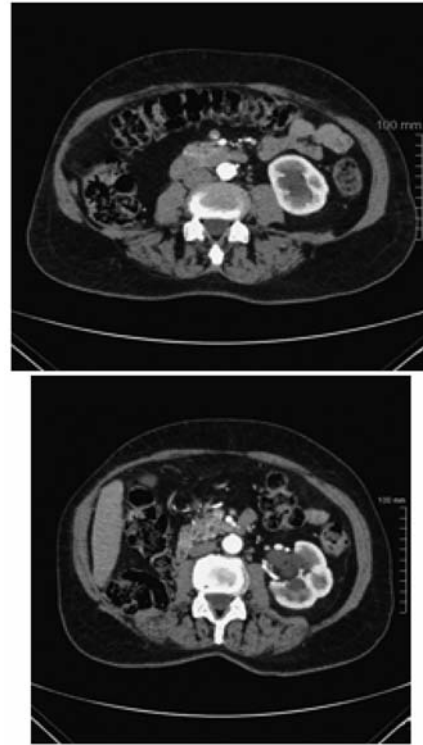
Abdominal CT at the follow-up (October 2015).
